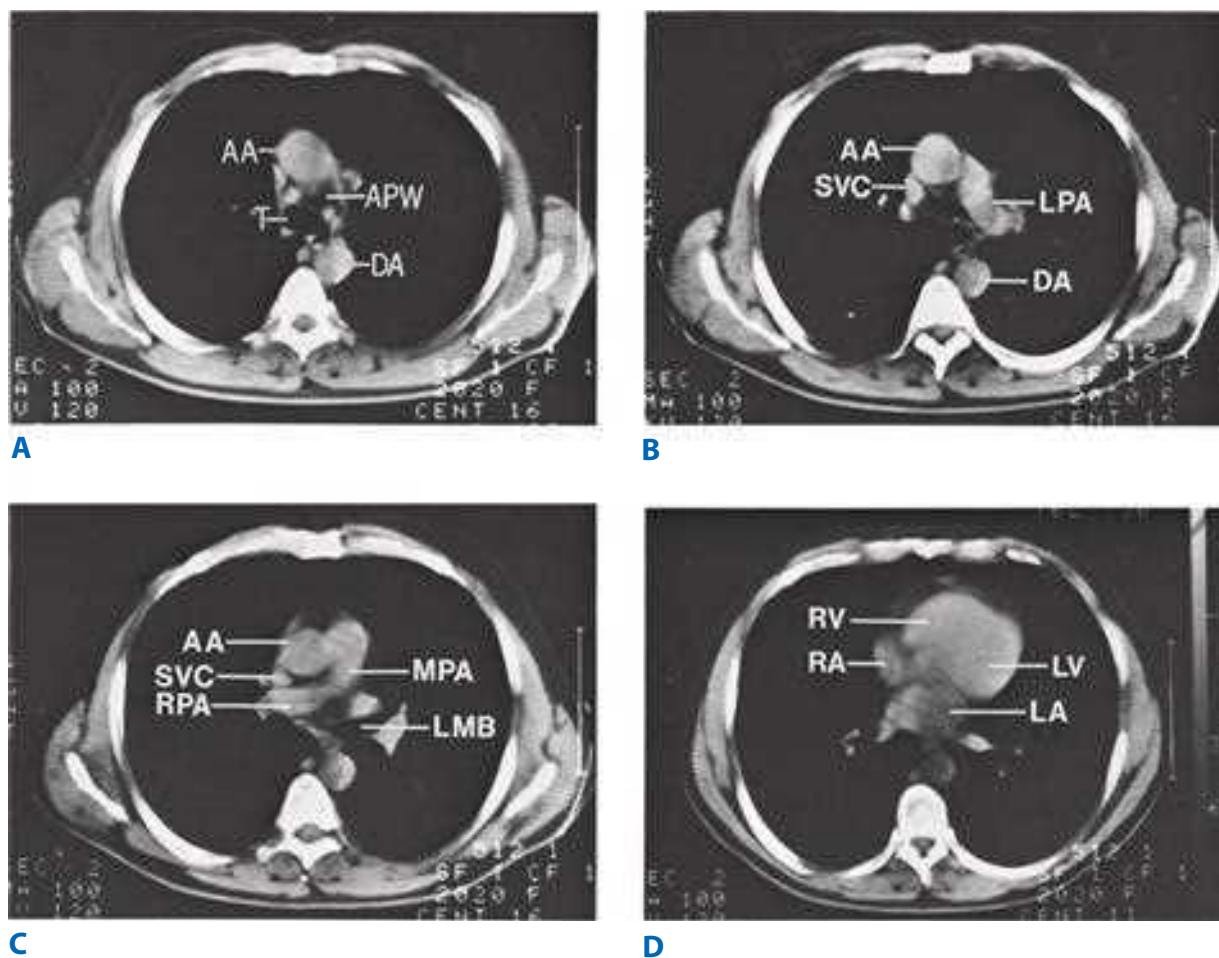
Spiral computed tomography scan showing normal transverse chest anatomy at four levels. A. At the level of the tracheal bifurcation, the aortopulmonary window can be seen. B. The origin of the left pulmonary artery can be seen at a level 1 cm inferior to A. C. The origin and course of the right pulmonary artery can be seen at this next most cephalad level. The left upper lobe bronchus can be seen at its origin from the left main bronchus. D. Cardiac chambers and pulmonary veins are seen in the lower thorax. AA = ascending aorta; APW = aortopulmonary window; DA = descending aorta; LA = left ventricle; LMB = left main bronchus; LPA = left pulmonary artery; MPA = main pulmonary artery; RA = right atrium; RPA = right pulmonary artery; RV = right ventricle; SVC = superior vena cava; T = trachea.
